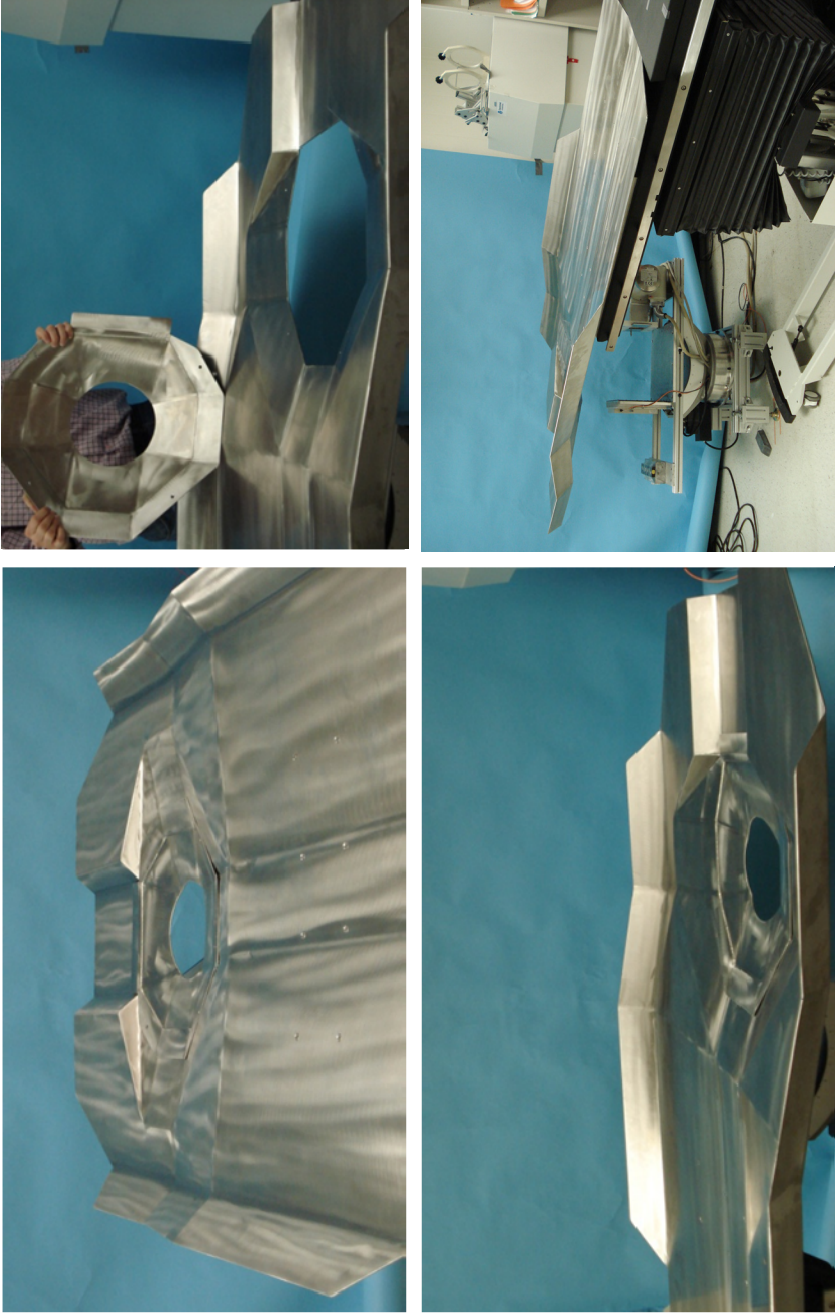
Photographs of the manufactured custom designed patient bed in different orientations. Note the torso section of the bed (top right) that can be removed to increase access to the patient breast and chest wall. (Bottom right) The new bed integrated with the Biodex positioning system and positioned over the original independent CT system.
